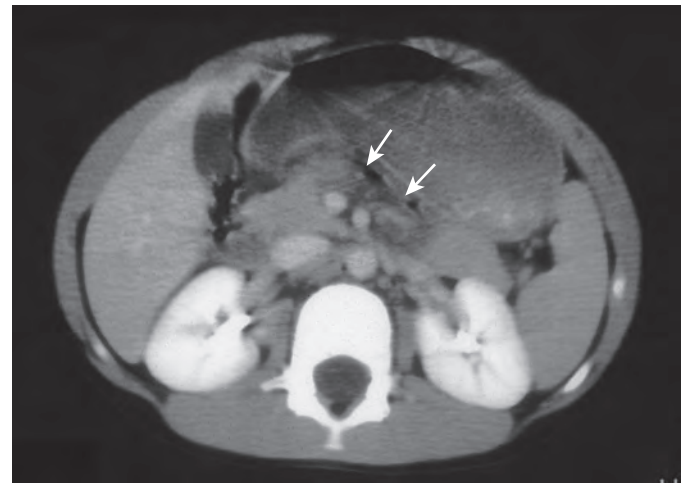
Pancreatic contusion. The CT scan through the pancreas reveals focal low attenuation in the body of the pancreas caused by contusion (arrows) in a young boy after abdominal trauma from a bicycle handlebar.
